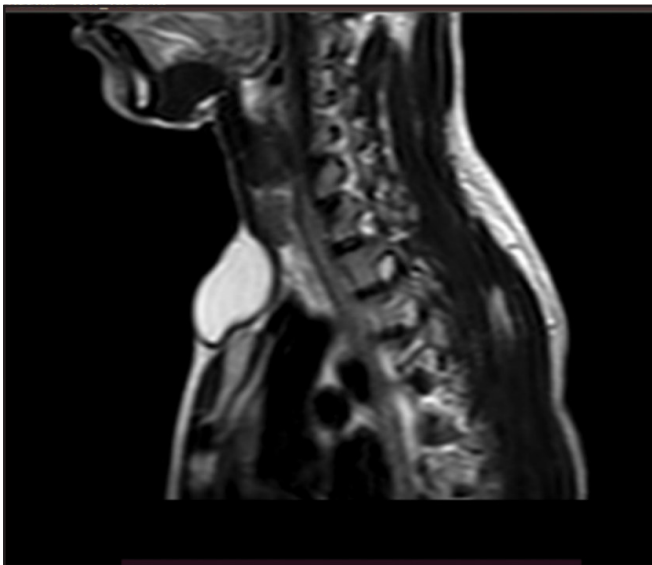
T2 weighted MRI image of the unilocular suprasternal cystic lesion
